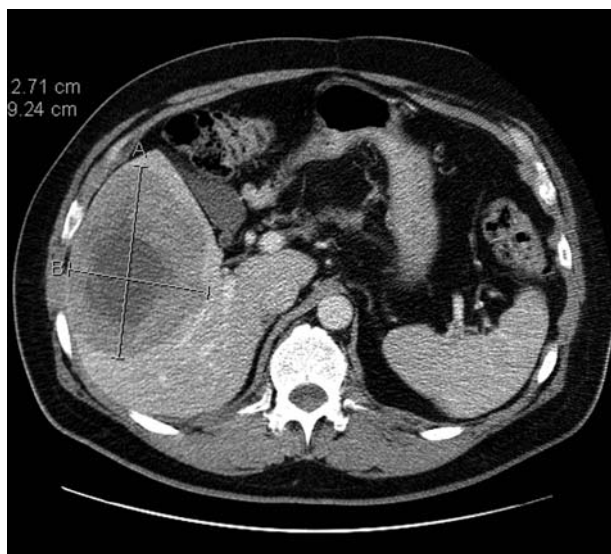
The larger liver metastasis detected on a CT scan before the start of IM in case 1.
